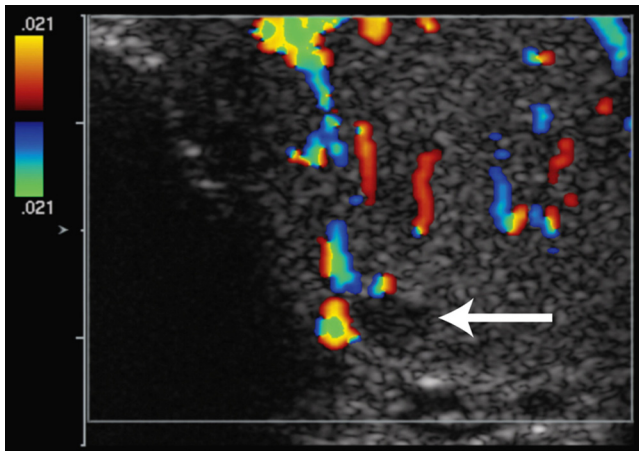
44-year-old male with Leydig-cell tumor. Transverse color Doppler sonogram of the right testis focusing on the hypoechoic nodule demonstrates flow adjacent to the nodule, but not within the nodule (arrow).
